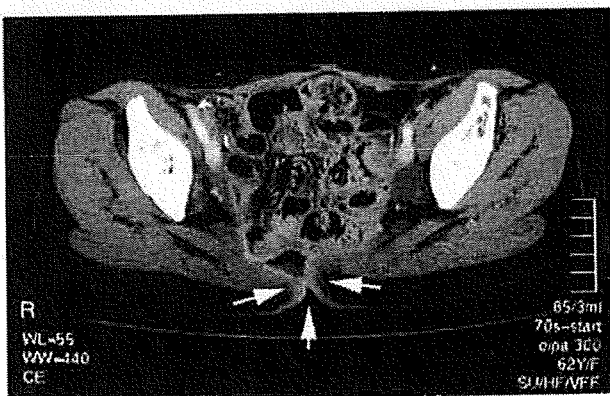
A preoperative computed tomogram indicated the presence of a fistula (arrows).
